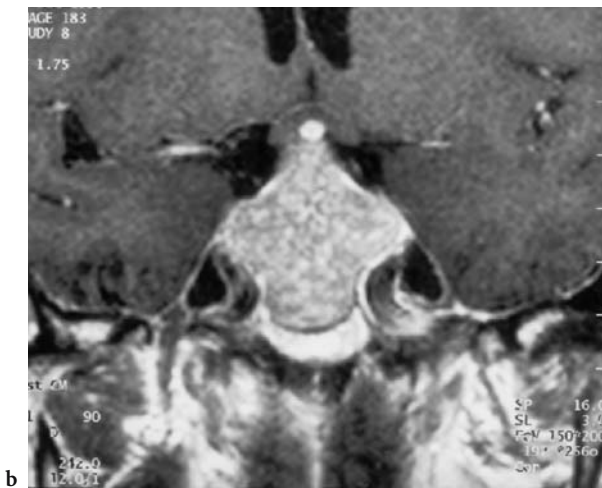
A 64-year-old woman with a bitemporal visual defect detected on ophthalmologic control examination. Diagnosis: cystic, degenerated, nonhormogenic pituitary adenoma. MRI: a Coronal T1-weighted native view, showing a predominantly hypointense tumor of the pituitary gland, associated with widening of the sellar lumen, and extension primarily into the suprasellar region, leading to caudal, left accentuated elevation and inferior compression of the chiasm. In addition, the remaining region of the pituitary gland, visualized in the right area of the image, appears hypointense. b Corresponding contrast-enhanced image demarcating the cystic tumor from the remaining pituitary gland. c Midsagittal T1-weighted image with posterior dislocation of the chiasm. The pituitary stalk is not identified, although the pointed infundibular recess of the third ventricle (*white arrow*) is seen in the posterior region of the cystic tumor. d Axial T2-weighted image confirming the fluid character of the cyst
